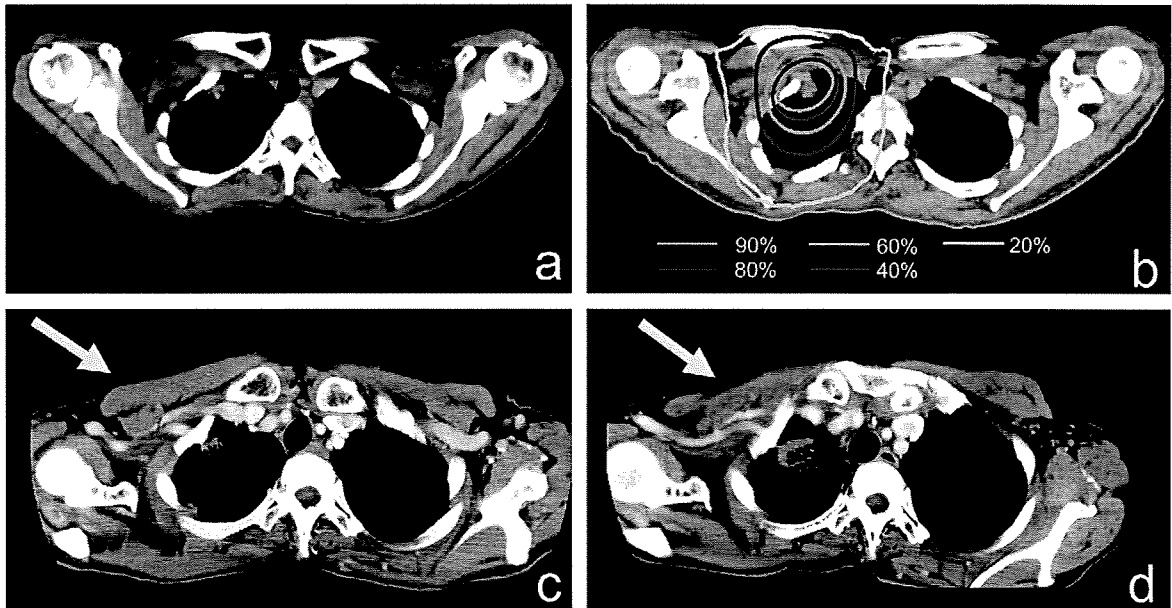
Primary lung cancer (cT1N0M0, adenocarcinoma) in right upper lobe (Patient 4 in Tables 1 and 2). Axial computed tomography image before (a) irradiation and (b) isodose distributions. The second curve from inside indicates 80% isodose and corresponds with planning target volume. Patient complained of numbness of ipsilateral fingers 2 months after irradiation. Computed tomography images showed soft-tissue density in right axilla. (c,d) Subsequently, density enlarged and seen as soft-tissue mass on computed tomography (arrows). Patient had interdigital and thenar eminence muscle atrophy of ipsilateral hand 18 months after irradiation. These symptoms were diagnosed as neuropathy of brachial plexus resulting from soft-tissue mass. Soft-tissue mass grew until 17 months after irradiation, after which it stopped. Primary lesion also remained unchanged and was judged as well controlled. However, computed tomography 29 months after irradiation revealed ipsilateral hilar metastatic adenopathy.
